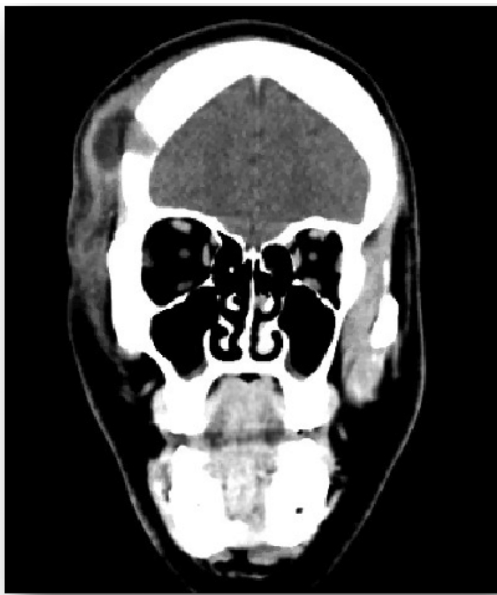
CT scan identifying a 2-cm lytic lesion in the frontal bone.
